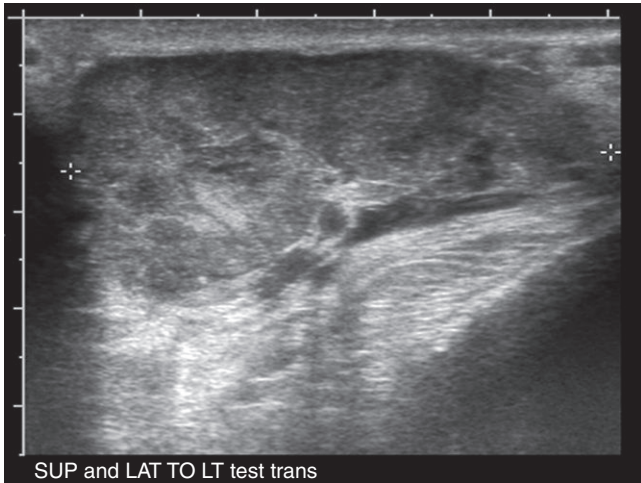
Ultrasound of the left inguinal region demonstrating this 2 cm × 3 cm × 4 cm mass-like lesion separate from the left testis.
